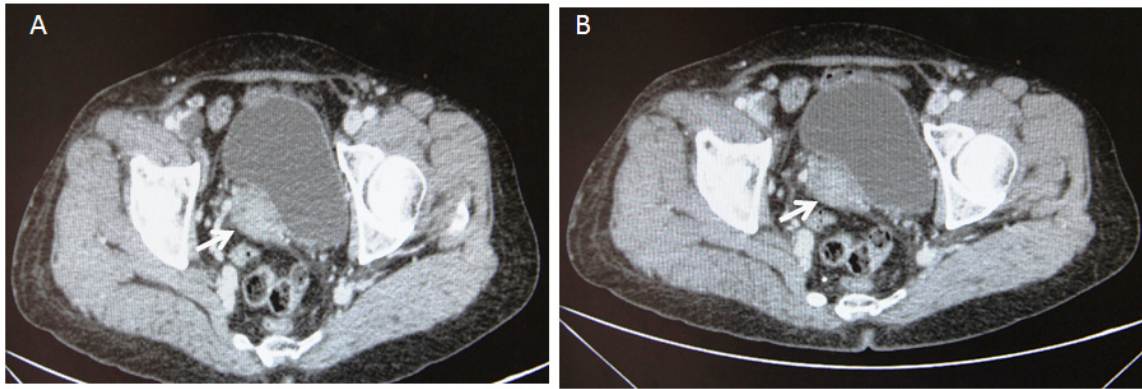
Contrast-enhanced computed tomography demonstrating distension of the left common femoral vein due to an intraluminal hypoattenuating mass lesion (arrow) attached to the bladder wall (A). The mass was presumed to be a deep vein thrombus (B).
